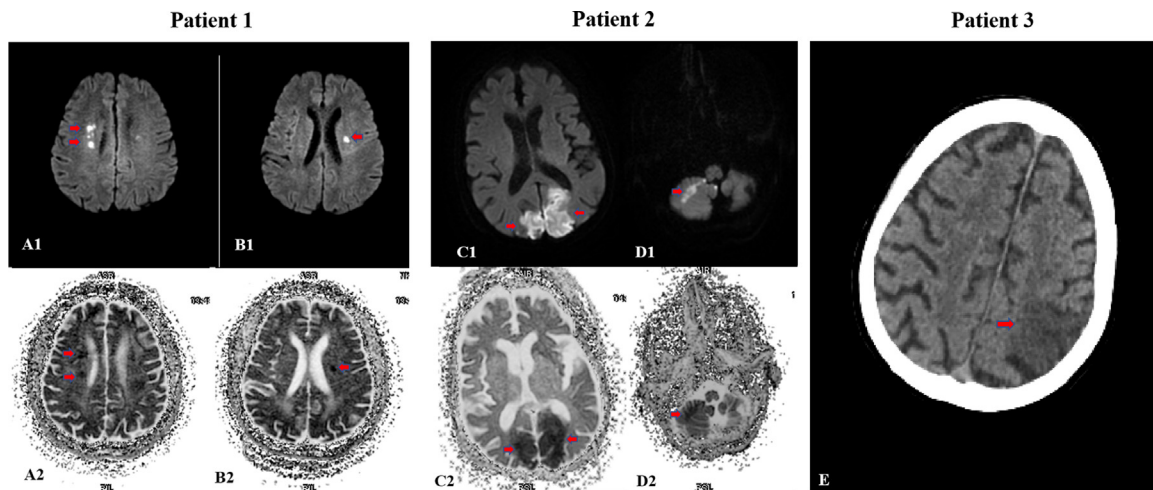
A. Representative lung and B. brain imaging in COVID-19 patients with ICVD. Case patient 1: Diffusion weighted images (DWI) showed multiple subcortical periventricular hyperintensities (A1-B1) with decreased ADC values (A2, B2). Case patient 2: DWI revealed hyperintensities in bilateral occipital lobe (C1) and right cerebellar hemisphere (D1) with reduced apparent diffusion coefficient (C2, D2). Case patient 3: CT imaging showed hypodensity in the left parietal lobe (E).
